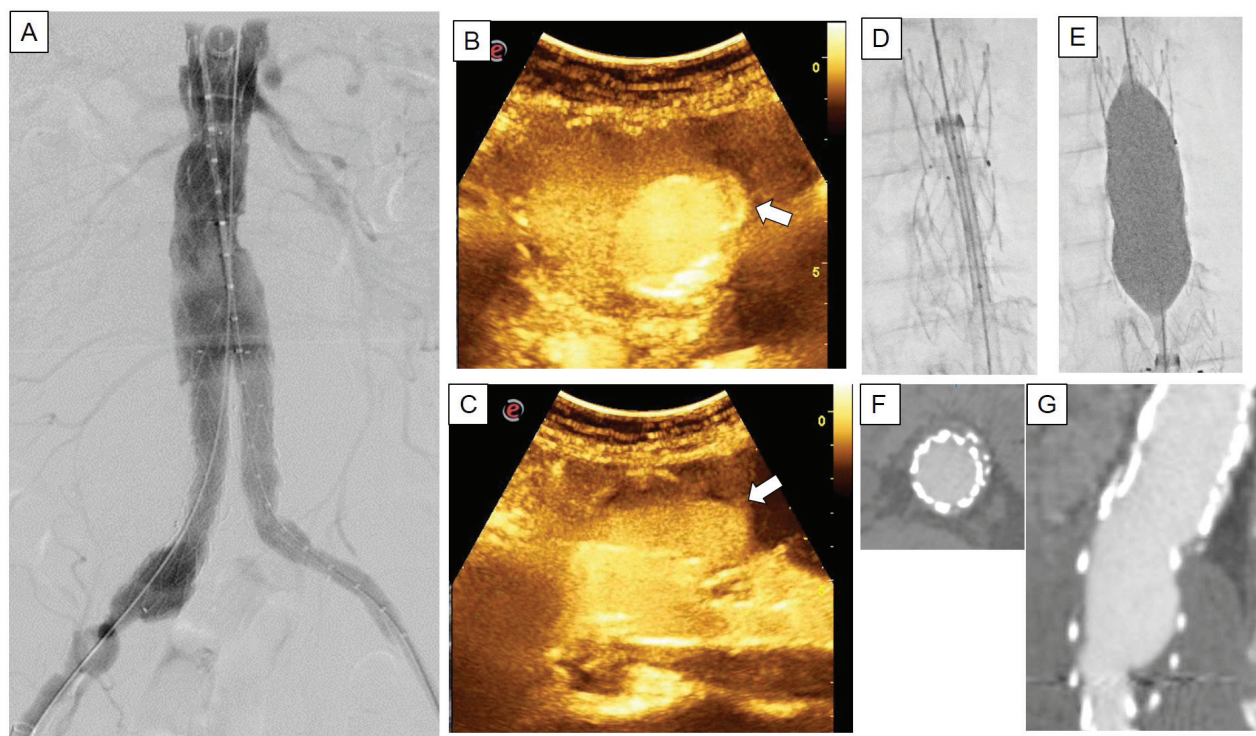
Diagnosis and intraoperative treatment of a type Ia endoleak (EL) undetected at completion digital subtraction angiography (DSA) (case #1). A) completion angiography showed no EL. B, C) intraoperative contrast-enhanced ultrasound (CEUS) identified a sac reperfusion with proximal EL (white arrows). D, E) intraoperative treatment of type Ia EL with Palmaz stent deployment. F, G) post-operative computed tomography angiography proved the EL absence.
